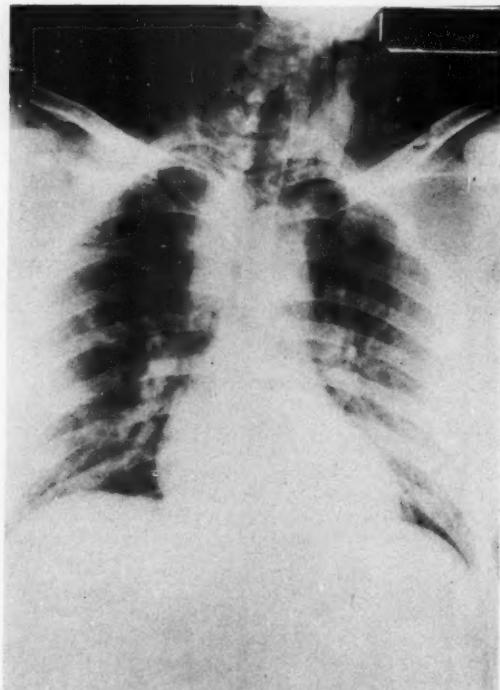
Roentgenogram of chest in posteroanterior projection in Case 2 showing subcutaneous emphysema and no evidence of pneumothorax.
